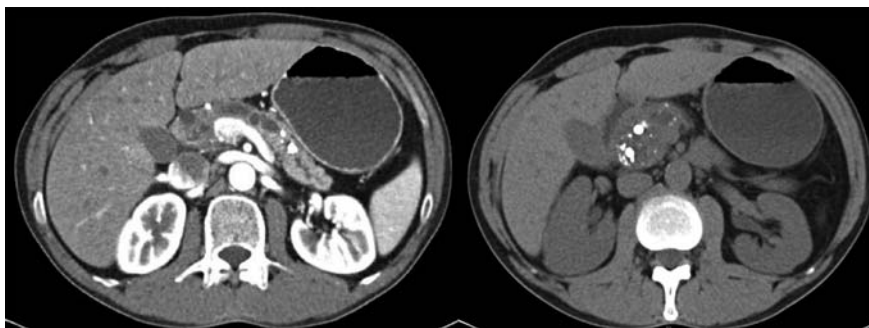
Preoperative CT scan demonstrating dilated pancreatic duct on contrast scan and severely calcified and diseased pancreatic head on non-contrast images
